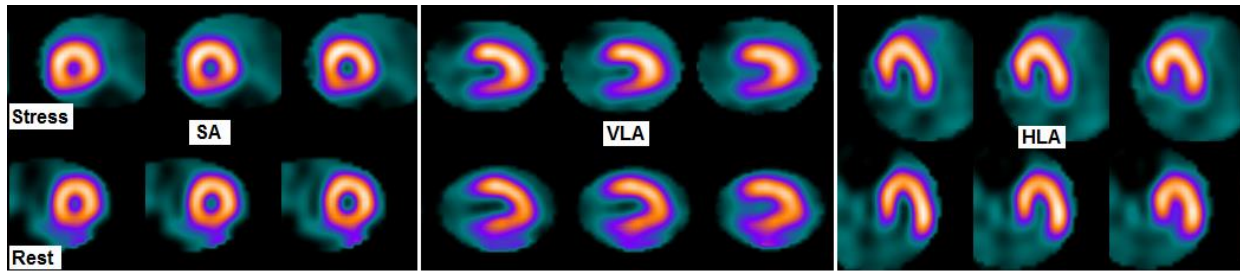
Two-day ^{99m}Tc -MIBI protocol with exercise stress and gated SPECT-CT images shows normal perfusion SA, Short axis; VLA, Vertical line axis; HLA, Horizontal long axis
